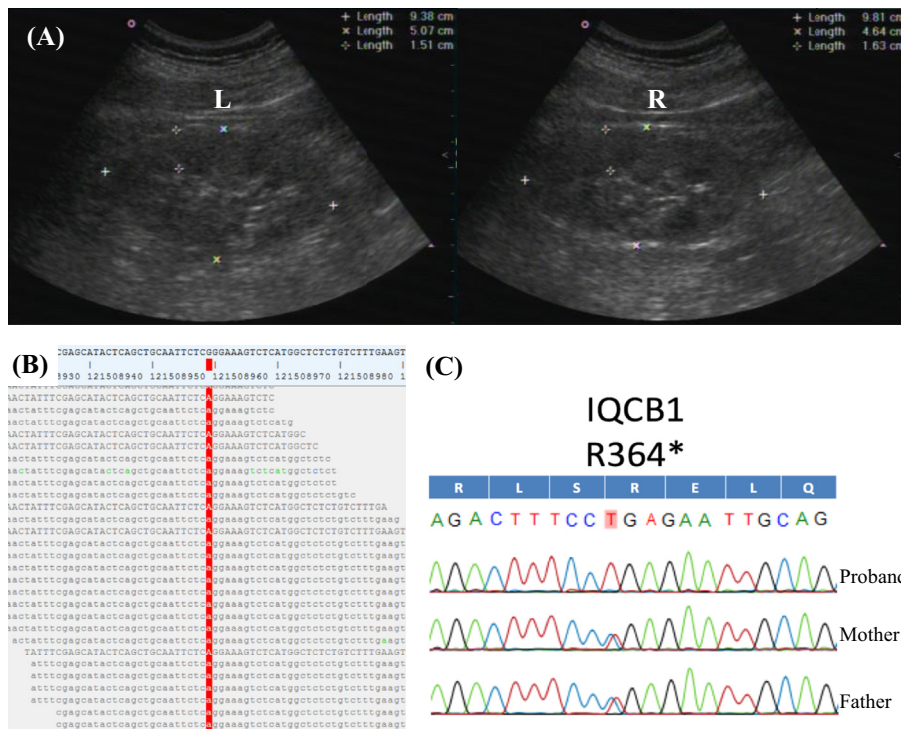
The kidney sonography showed multiple medullary cysts and bilateral mild atrophic kidneys (A). Whole exome sequencing (B) and Sanger sequencing (C) of compound homozygous non-sense p.R364* (c.1090C > T) mutations of *IQCB1* gene. L, left kidney; R, right kidney.
